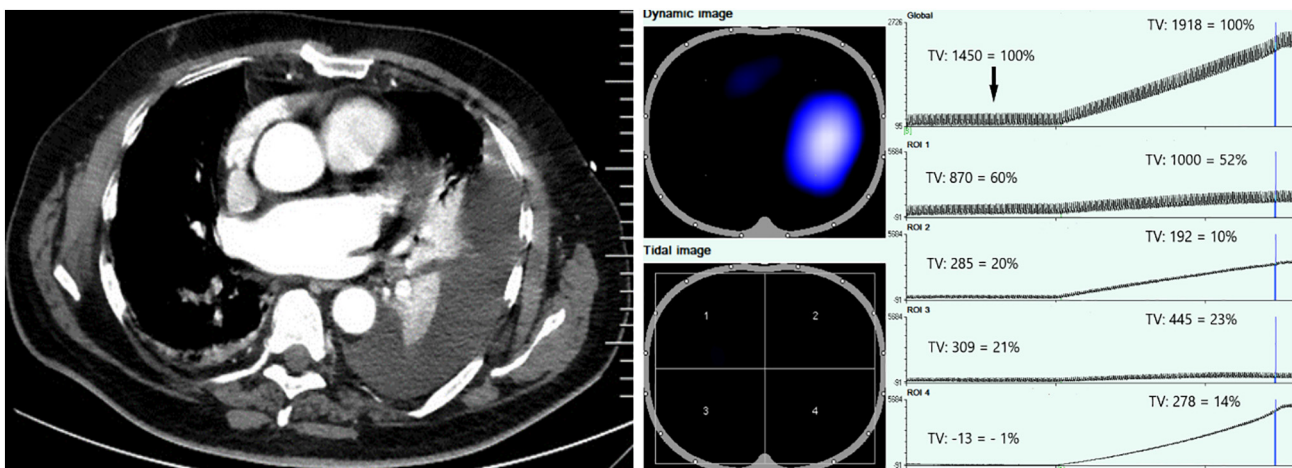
Left: CT scan, left-sided pleural effusion, patient with urosepsis. Right: the same patient, EIT record, before and during evacuation of PLE, PulmoVista 500 system, modified. Region-of-interest (ROI) in quadrants. Black arrow—time of tidal variation (TV) distribution (%) in ROI before evacuation. Vertical blue line—time of the dynamic image in the upper left corner and corresponding TV distribution (%) in ROI after PLE evacuation. (For interpretation of the references to colour in this figure legend, the reader is referred to the web version of this article.)
